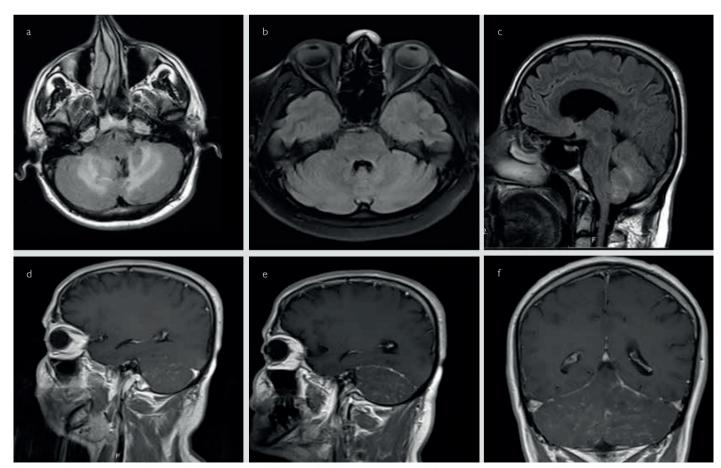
a-f. Brain MRI lesions of the second case. Axial FLAIR (a,b), Sagittal flair (c), Sagittal post contrast(d) and Coronal T1 post contrast(f) weighted MR images show the lesions of second case
